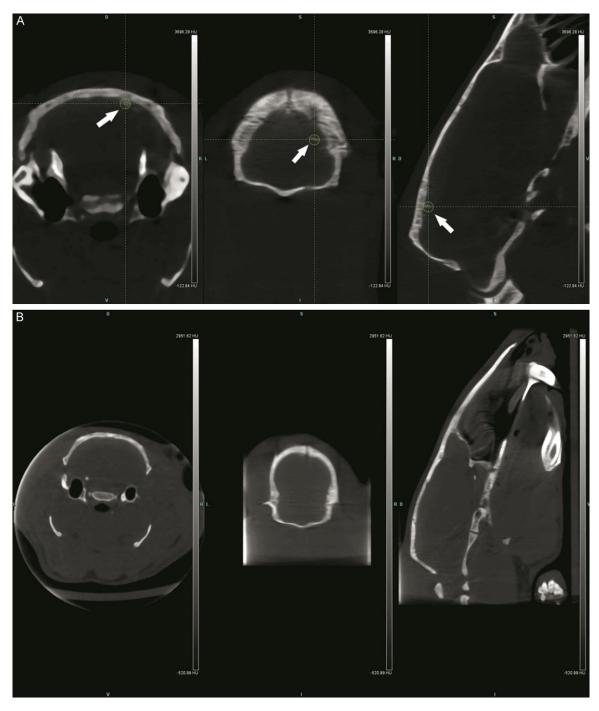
Micro-PET/CT imaging after a mild traumatic brain injury. A. The arrows represent subarachnoid hemorrhage. B. There was no significant cerebral hemorrhage or intracranial hemorrhage.
